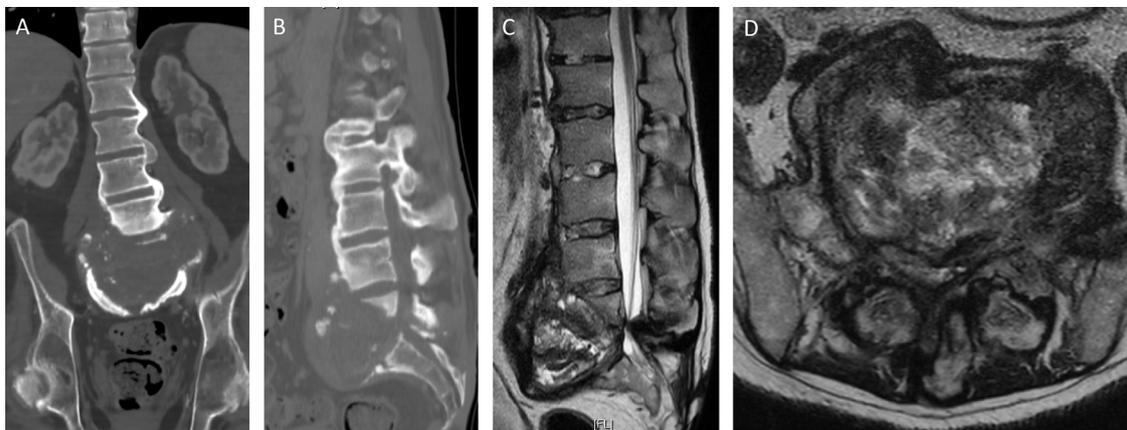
Aspect of pseudotumoral L5-S1 Charcot spine in a C5 tetraplegic patient with DISH (case 2). Coronal (A) and sagittal (B) reconstructions from axial spiral CT scan on the left side, and sagittal (C) and axial (D) T2-weighted MRI images of the lumbar rachis on the right side.
